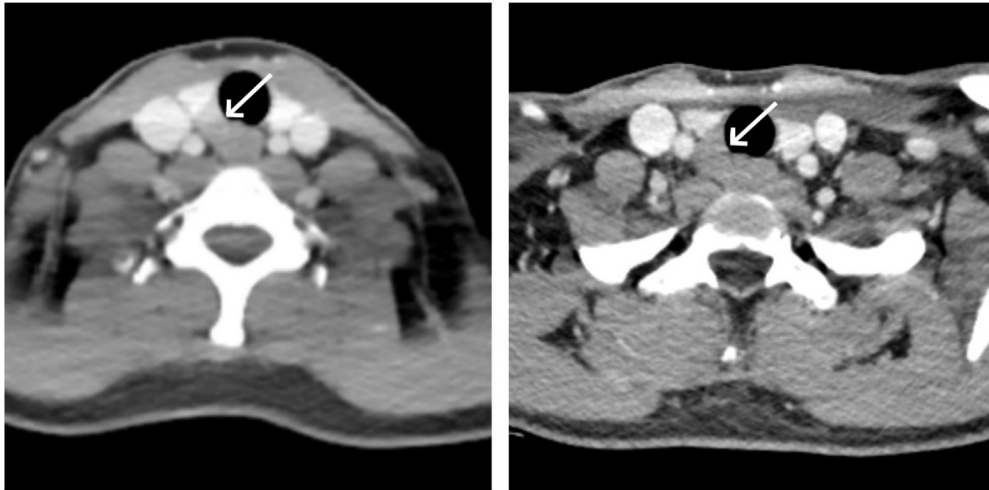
Enhanced CT images of trachea and thyroid. (A) A nodule with slight enhancement (similar to cervical muscle) (white arrow) was on the right side of the trachea, dorsal to the right lobe of thyroid. (B) The nodule (white arrow) invaded posterior wall of trachea and esophagus.
